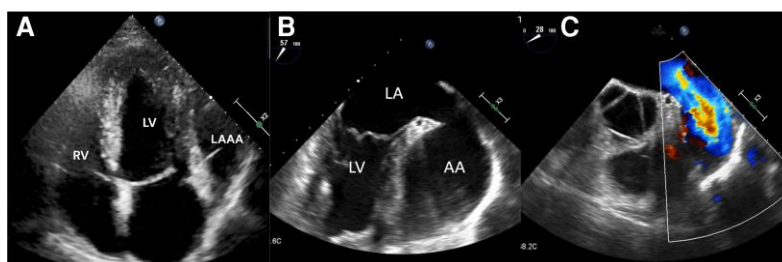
Echocardiography. (A) Transthoracic apical four-chamber view with the left atrial appendage aneurysm (LAAA) compressing the left ventricle lateral wall. (B) Mid-oesophageal two-chamber view showing the LAAA in its entire dimensions and showing no thrombi inside. (C) Mid-oesophageal short-axis colour Doppler view shows high velocities inside the auricle. LA, left atrium; AAA, atrial appendage aneurysm; LV, left ventricle.
